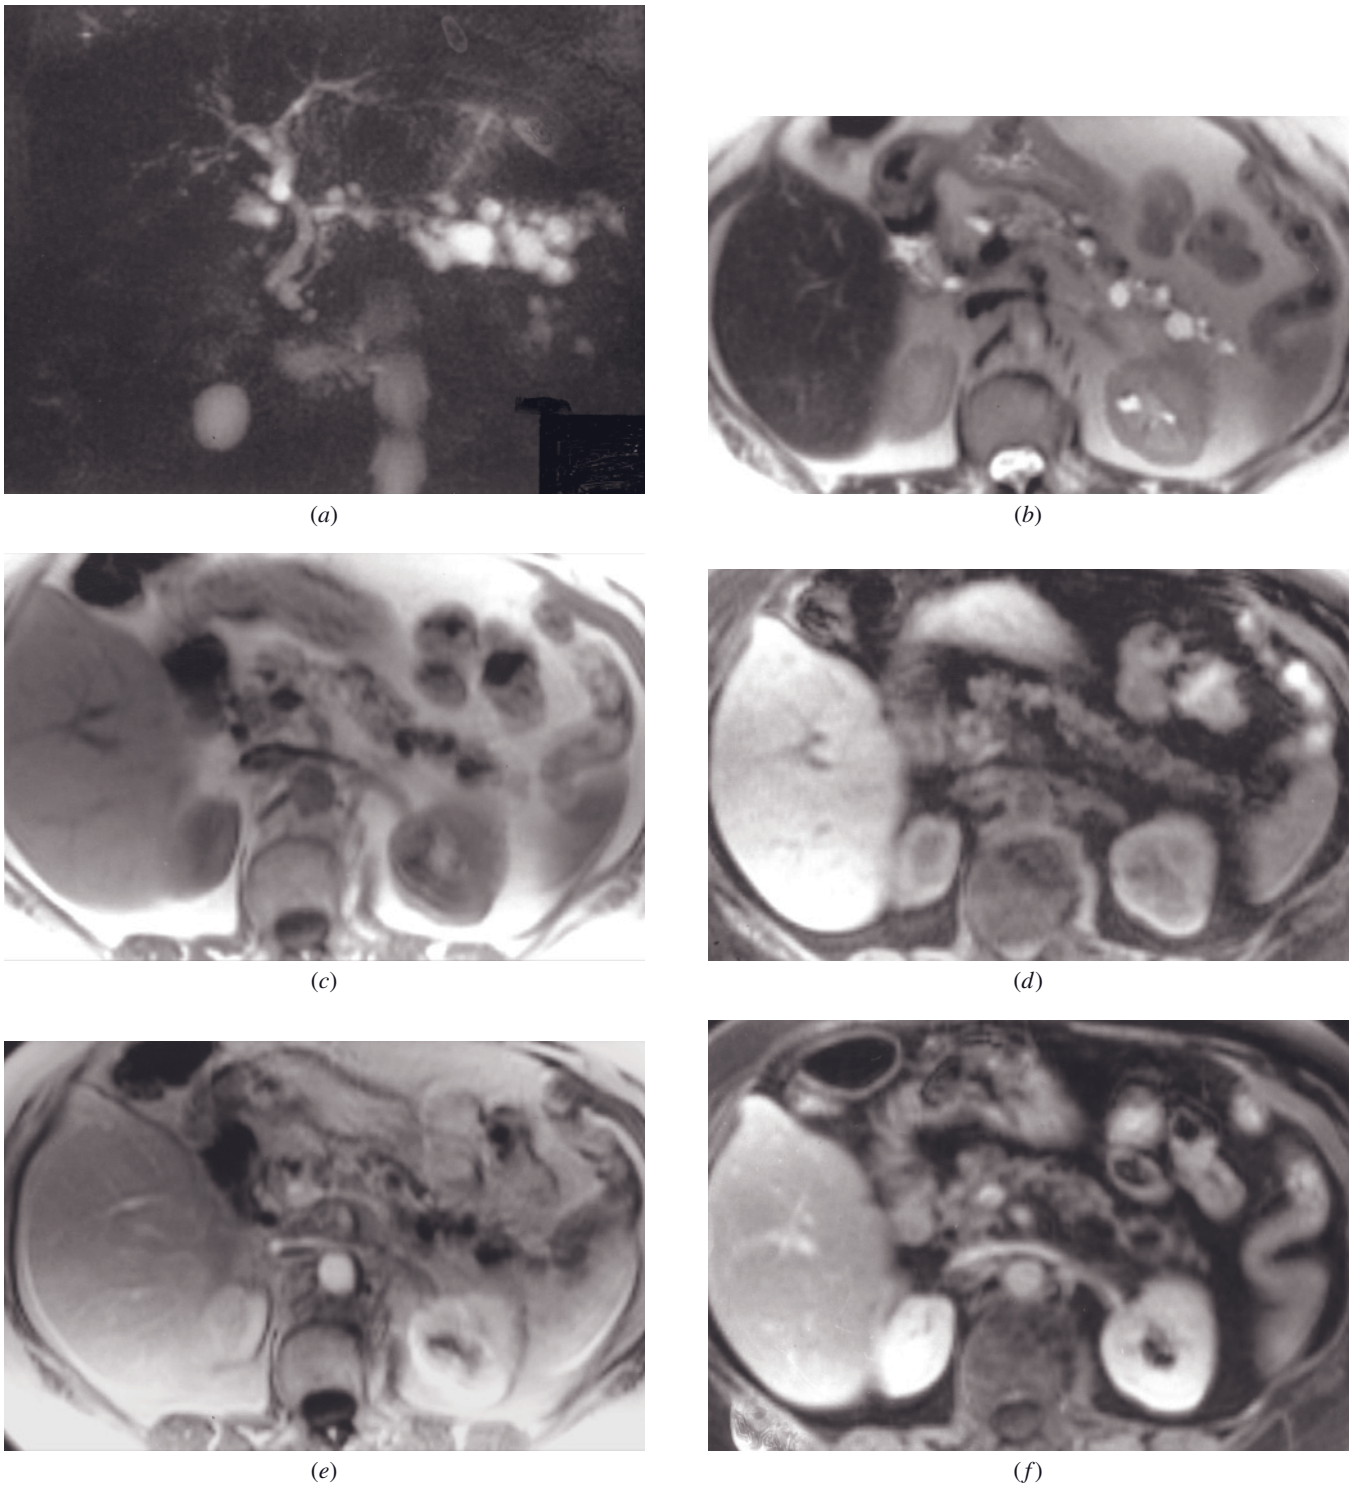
Chronic pancreatitis with multiple small pseudocysts. MRCP (*a*), T2-weighted SS-ETSE (*b*), T1-weighted SGE (*c*), T1-weighted fat-suppressed SGE (*d*), immediate postgadolinium T1-weighted SGE (*e*), and 90-s postgadolinium fat-suppressed SGE (*f*) images. Multiple small pseudocysts are present throughout the atrophic background pancreatic parenchyma and appear hyperintense on T2-weighted images (*a*, *b*) and hypointense on T1-weighted images (*c*, *d*) and show lack of enhancement on early (*e*) and late (*f*) postgadolinium images, consistent with pseudocysts.
